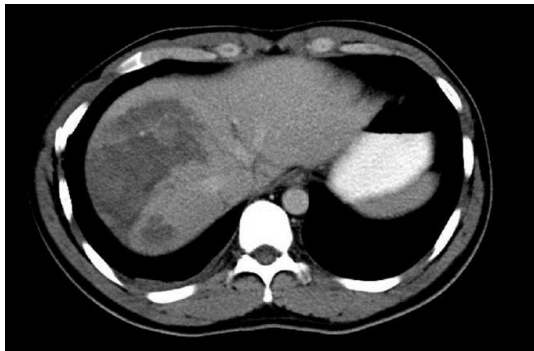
52 Year old female with history of road side accident. Axial CT image shows liver injury grade IV
